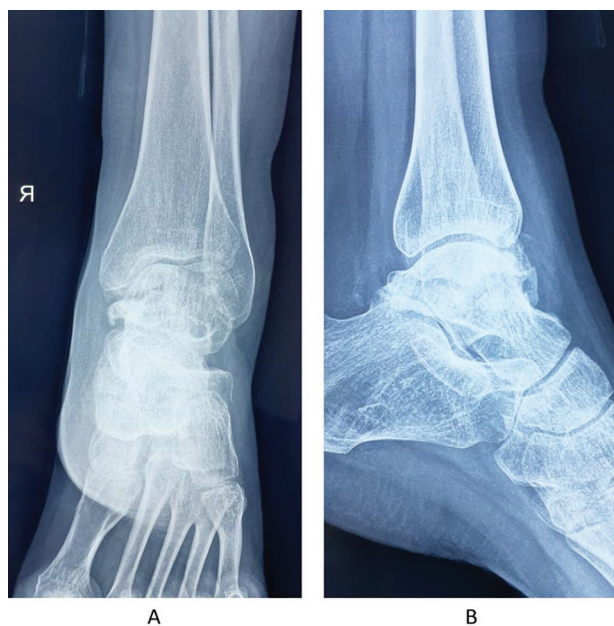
Radiography 24 months after operation shows well-maintained density of the talus; A - Anterior Posterior (AP) dorsoplantar radiograph view and B - lateral radiograph view
